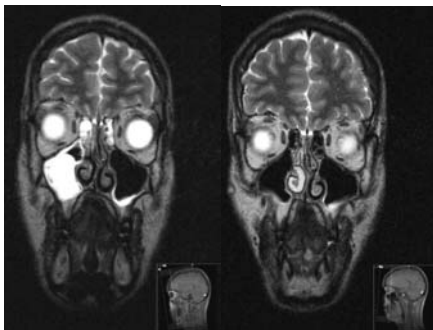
Coronal MRI (T2 weighted) slice of a patient before (left) and after (right) a three month once daily treatment with steroids (budesonide) using the PARI SINUS pulsating aerosol device.
